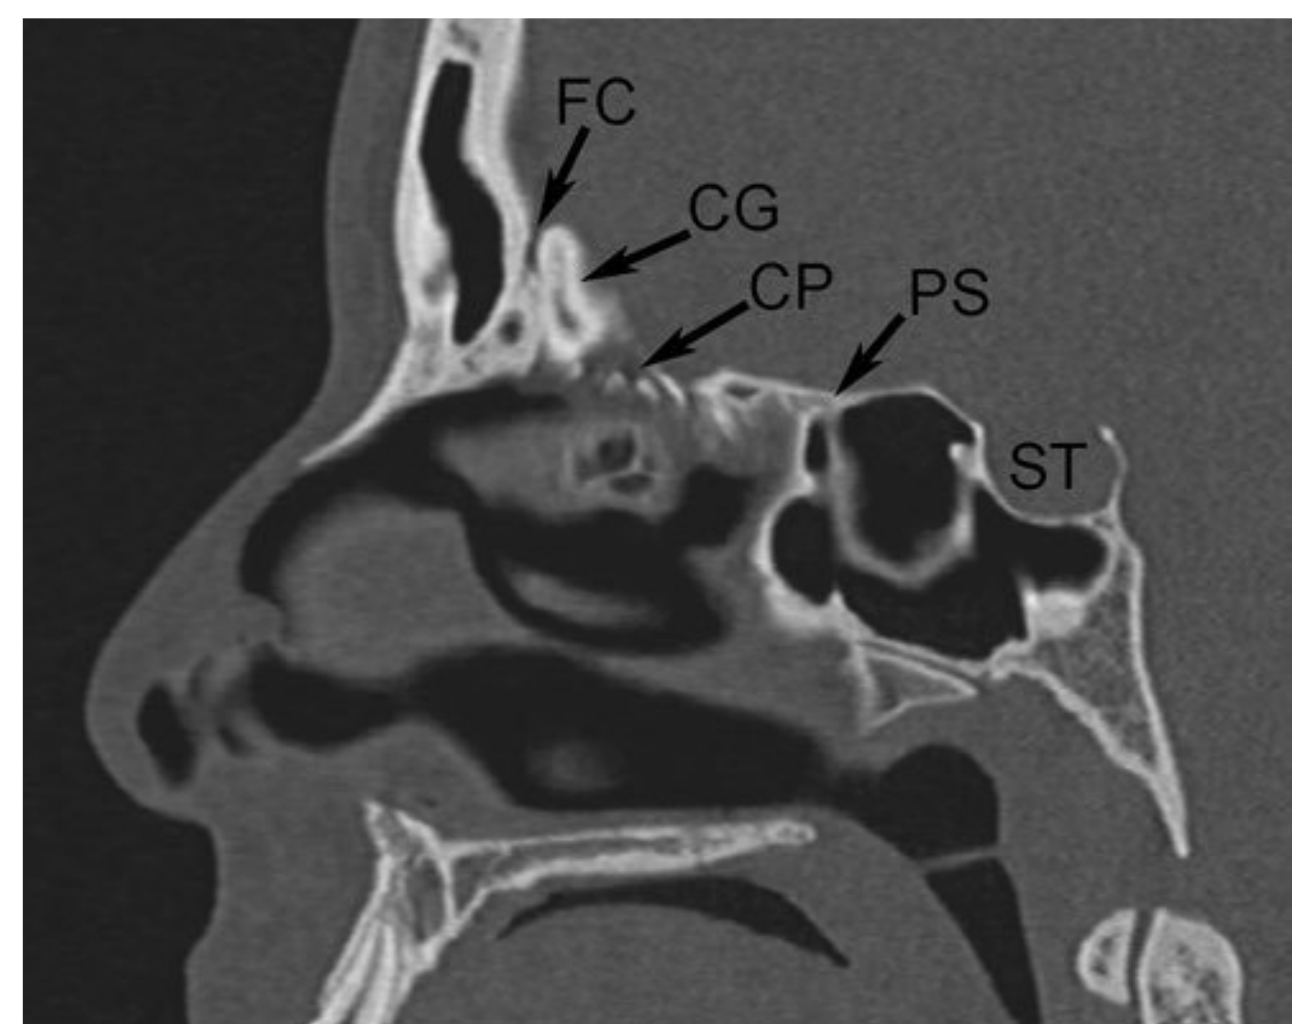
Midline sagittal reformation of CT scan through the sinuses demonstrates midline structures from front to back. The residual foramen cecum (FC) is identified anterior to the crista galli (CG). The perforations along the cribriform plate (CP) can be seen. The planum sphenoidale (PS) is the flat, ventral roof of the sphenoid sinus, anterior to the sella turcica (ST).
